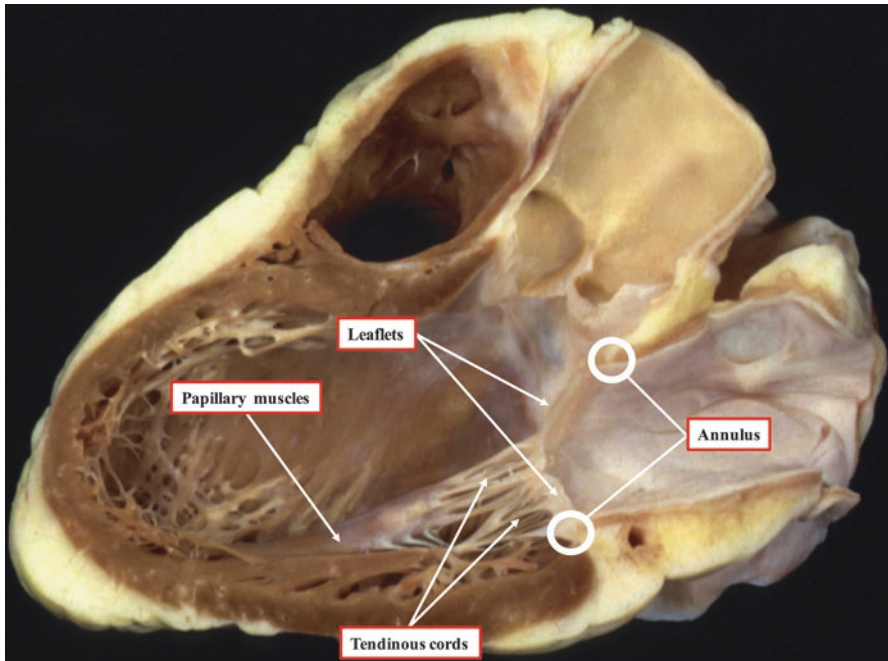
The parasternal long axis cut through the left side of the heart serves well to show the components of the mitral valvar complex. We will discuss in detail to the naming of, and controversies surrounding, the different parts of the complex as shown in the section
